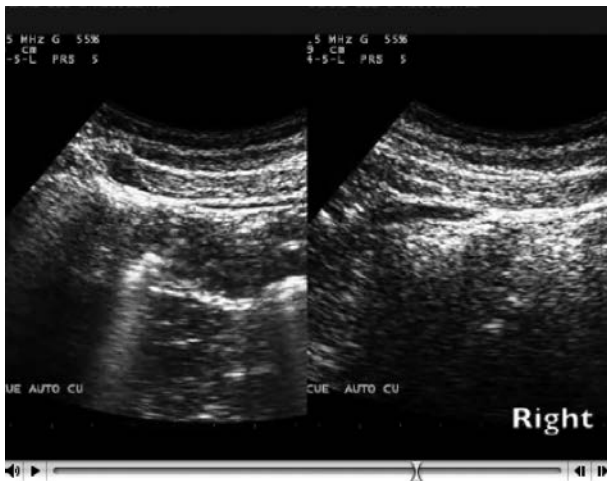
Screen capture from a real-time ultrasound imaging video of the left (on the left in this figure) and right (on the right) sides of the subject's abdominal wall during a response to a verbal cue for her to contract her pelvic floor. Note the difference in broadening and corseting of her transversus abdominis muscles.
